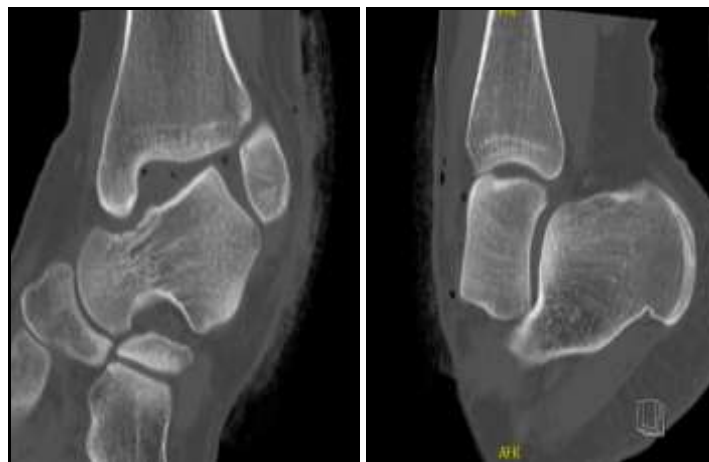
A CT scan was performed and confirmed the pure antero-lateral tibio-talar dislocation.
